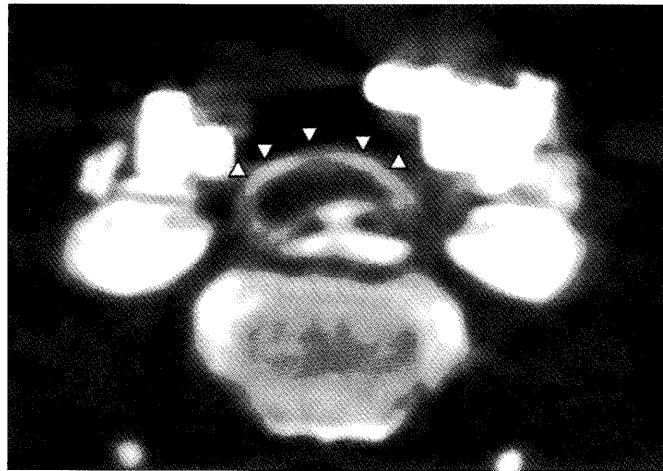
CT myelogram at the C3/4 level following the second surgery, demonstrating further decompression of the spinal cord compared with the preoperative CT myelogram. *Arrow heads* show the dorsal surface of the dural tube.
